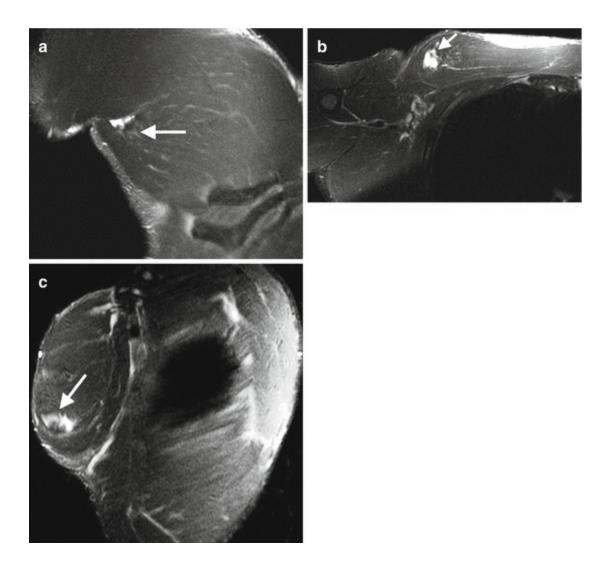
A 26-year-old-man with a partial tear of the myotendinous junction after a jiu-jitsu blow. Coronal fat-suppressed T2-weighted MRI shows focal discontinuity of myotendinous junction (*arrow*, a). Axial fat-suppressed T2-weighted MRI shows tendon retraction and a small fluid collection (*arrow*, b). Sagittal fat-suppressed T2-weighted MRI demonstrates tendon discontinuity in the distal third (*arrow*, c)
